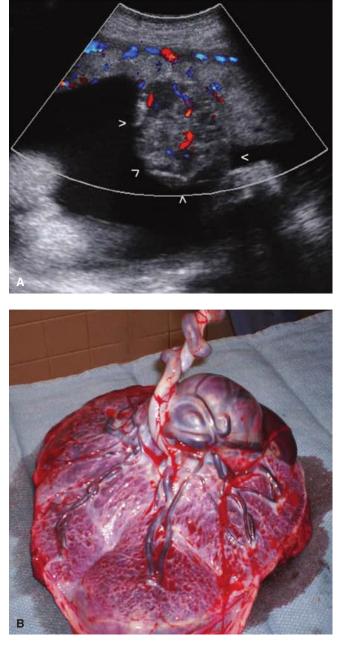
Placental chorioangioma. A. Color Doppler imaging displays blood flow through a large chorioangioma with its border outlined by white arrows. B. Grossly, the chorioangioma is a round, well-circumcised mass protruding from the fetal surface.
